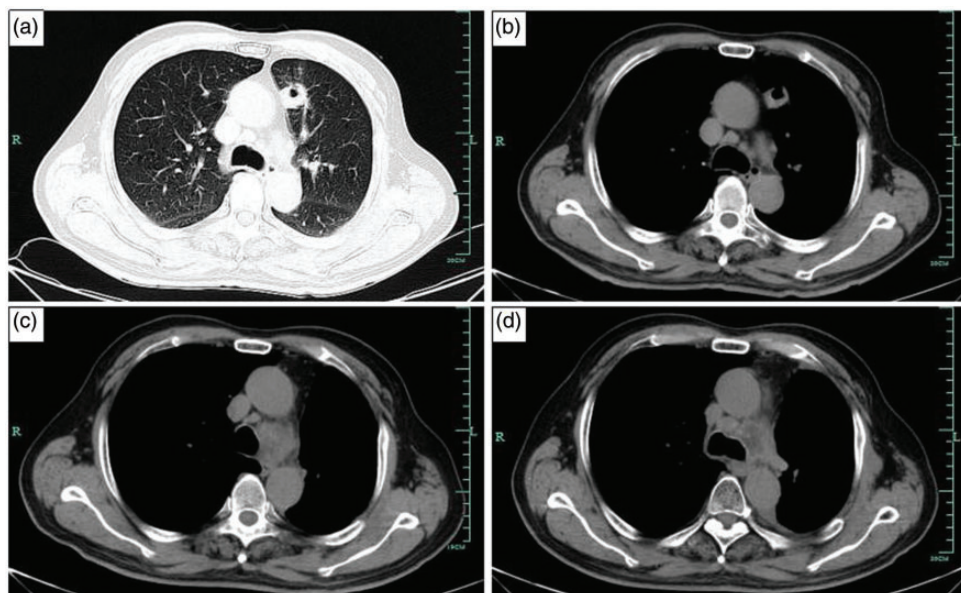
Computed tomography images. (a, b) A 25-mm-diameter mass with a cavity was found in the left upper lung lobe. (c) Six months after surgery, a large lymph node was found in the mediastinum. (d) The lymph node in the mediastinum was smaller after radiochemotherapy.
